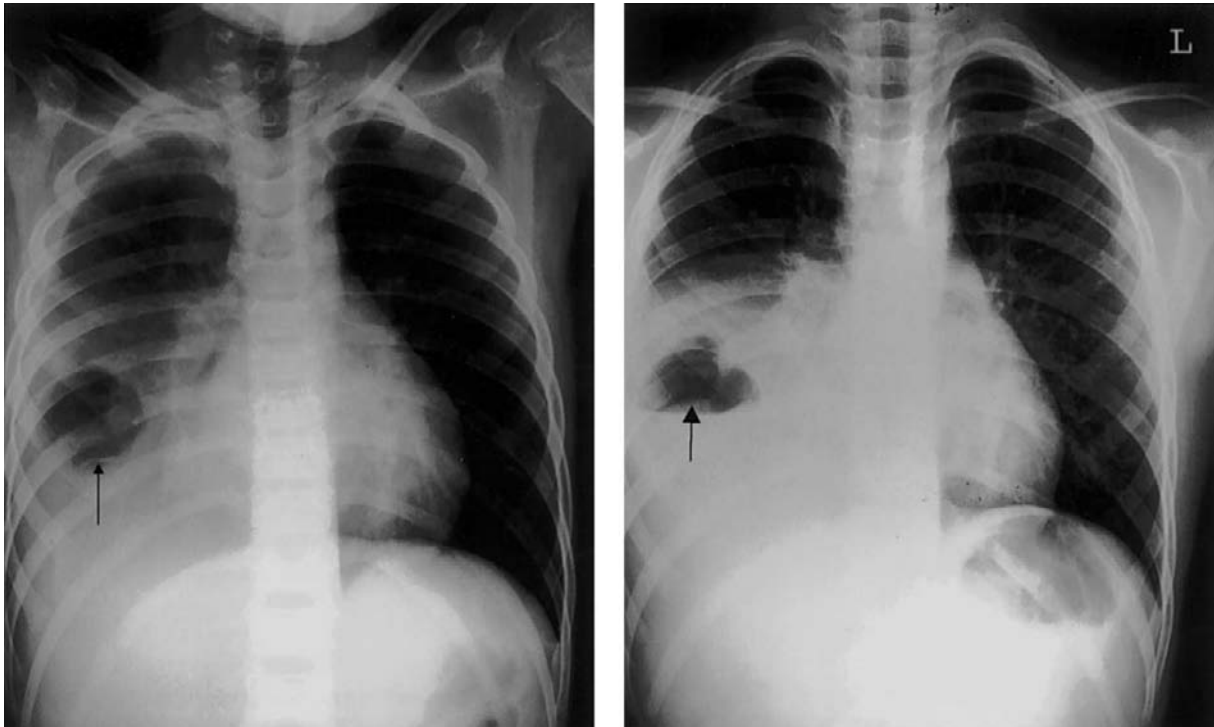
A, Supine chest radiograph revealing a cavitary lesion within a consolidated right lower lobe, as well as a small pleural effusion. The curvilinear opacity seen within the cavity (A, arrow) appears to be floating on the upright view (B, arrow).
